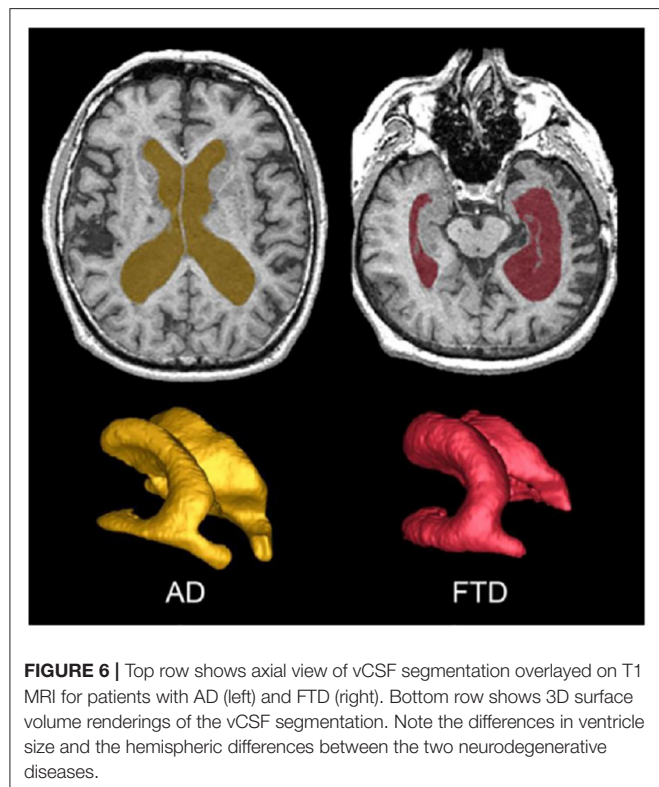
Top row shows axial view of vCSF segmentation overlaid on T1 MRI for patients with AD (left) and FTD (right). Bottom row shows 3D surface volume renderings of the vCSF segmentation. Note the differences in ventricle size and the hemispheric differences between the two neurodegenerative diseases.
